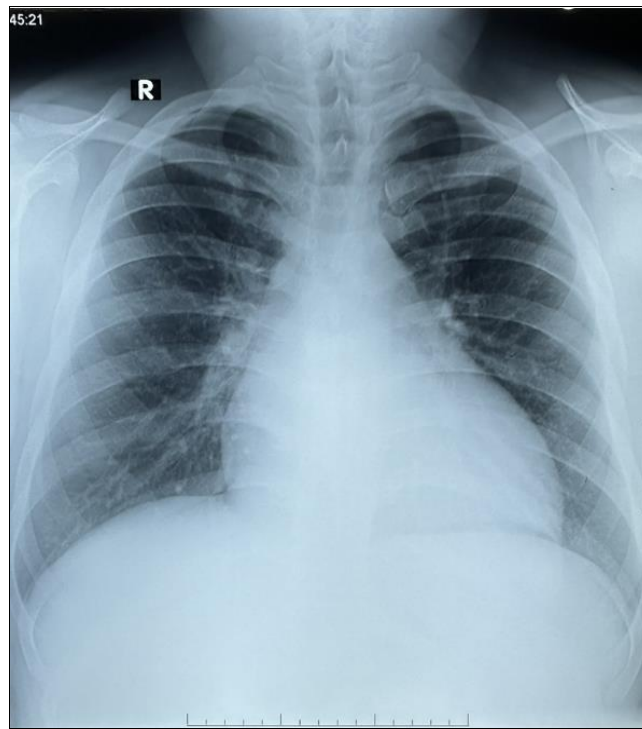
Chest Xrays showed a large cardiac shadow
